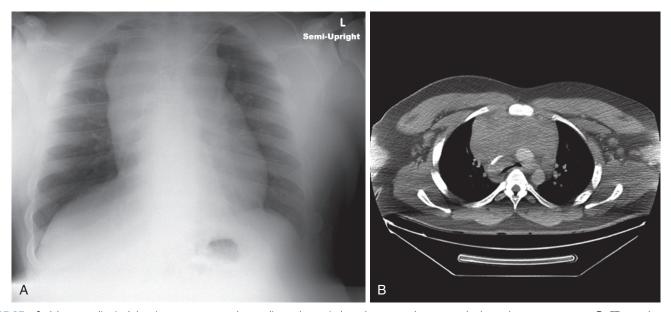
A, A large mediastinal thymic tumor seen on chest radiograph may induce dyspnea, orthopnea, and other pulmonary symptoms. B, CT scan demonstrating the anterior mediastinal thymic tumor.
